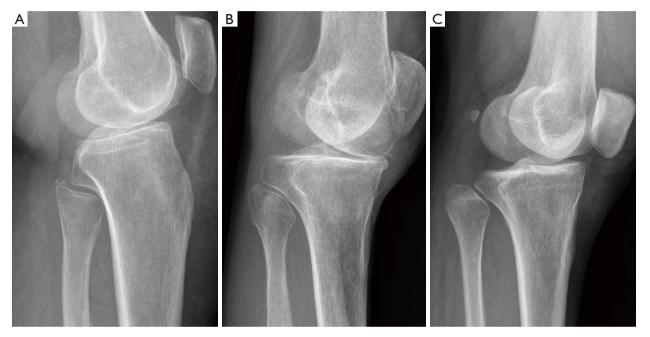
Representative radiographs images of different inclination angle of the PTFJ surface. (A) FIA and TIA are 13.99° and 13.15°, respectively. (B) FIA and TIA are 26.69° and 26.51°, respectively. (C) FIA and TIA are 45.39° and 44.25°, respectively. PTFJ, proximal tibiofibular joint; FIA, fibular inclination angle; TIA, tibial inclination angle.
